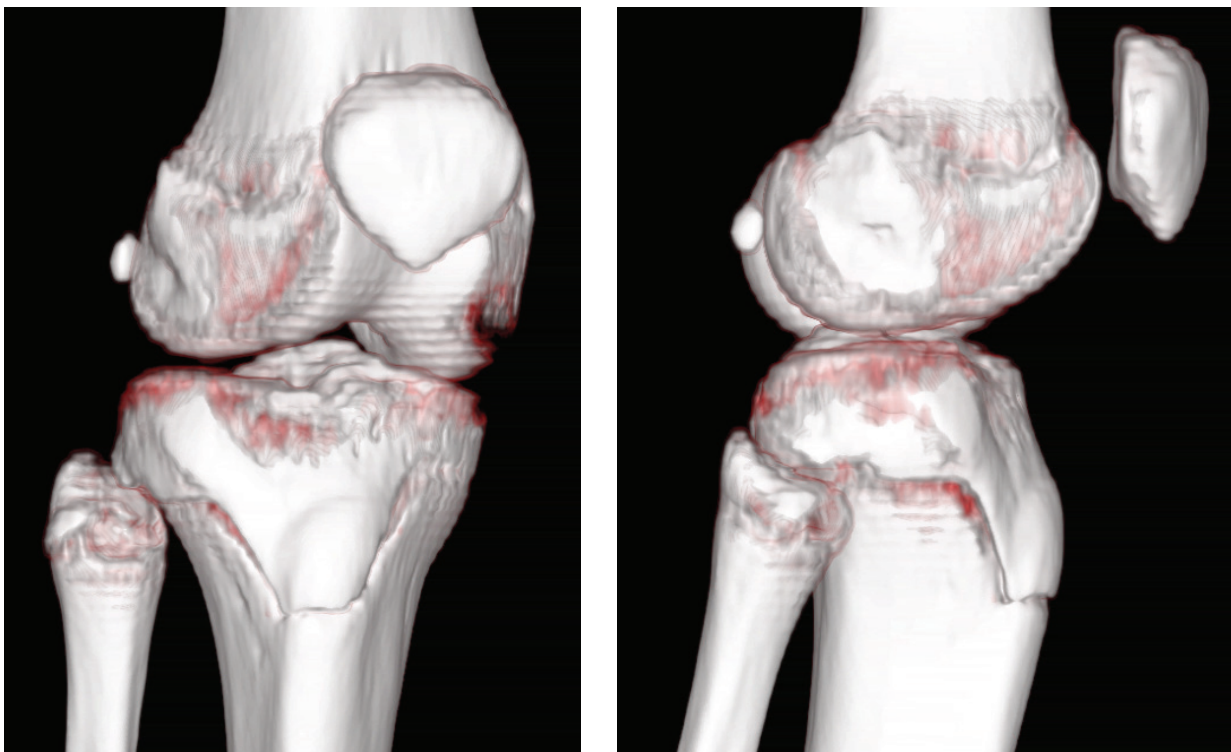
Computed tomography (CT) images of the right knee showing a fracture of the tibial tuberosity extending to the tibial condyles. Images of the right knee obtained on the day of the fracture.
